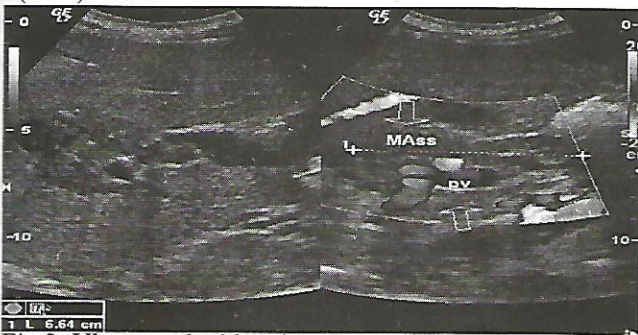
Ultrasound with colour Doppler of mass GB
